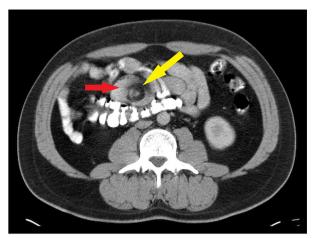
Abdo-pelvic CT scan with IV and PO contrast showing the whirlpool sign (yellow arrow) involving the jejunal loops (red arrow) at the level of the Treitz angle.
